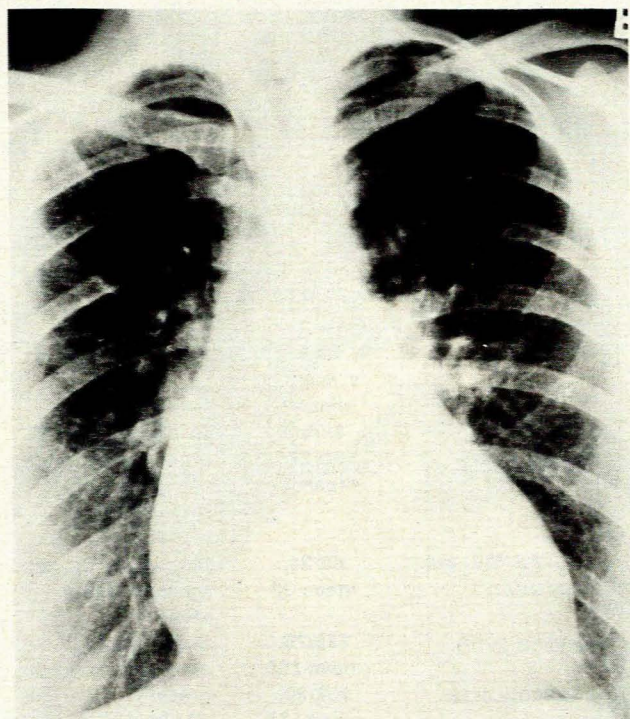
Postero-anterior chest radiograph demonstrating prominent main pulmonary artery segment and left atrial appendage.
